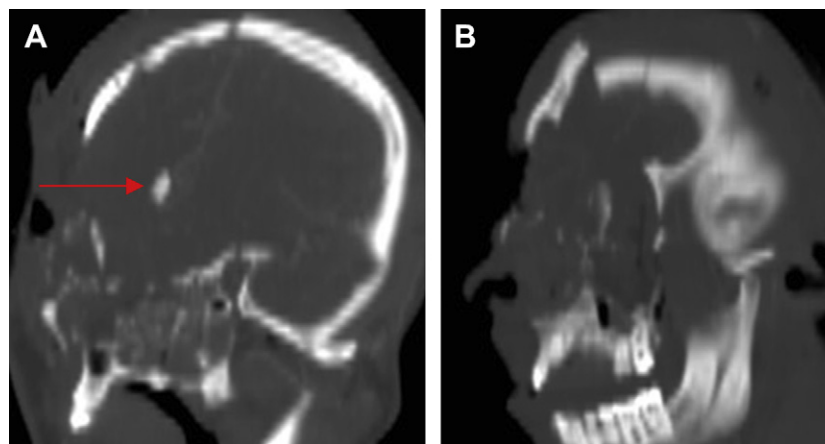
Selected coronal (A) and sagittal (B) reconstruction images obtained from initial postinjury CT. Note the severe disruption of the right anterior fossa floor, orbital bandeau, and frontal sinus. The red arrow depicts an indriven bony fragment adjacent to arterial tributaries from the right callosomarginal artery.
